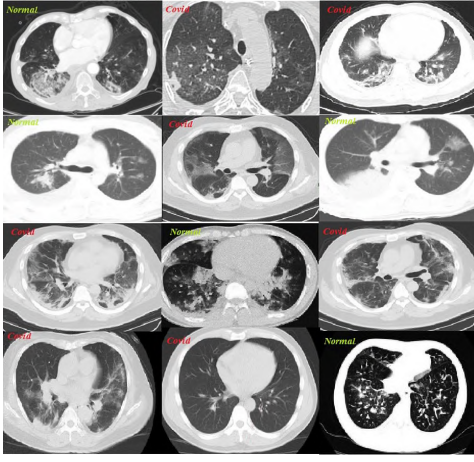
A few examples of the chest computed tomography (CT) images that is used in this study [15]. The positive and negative cases for COVID-19 are marked with Covid and Normal respectively.
